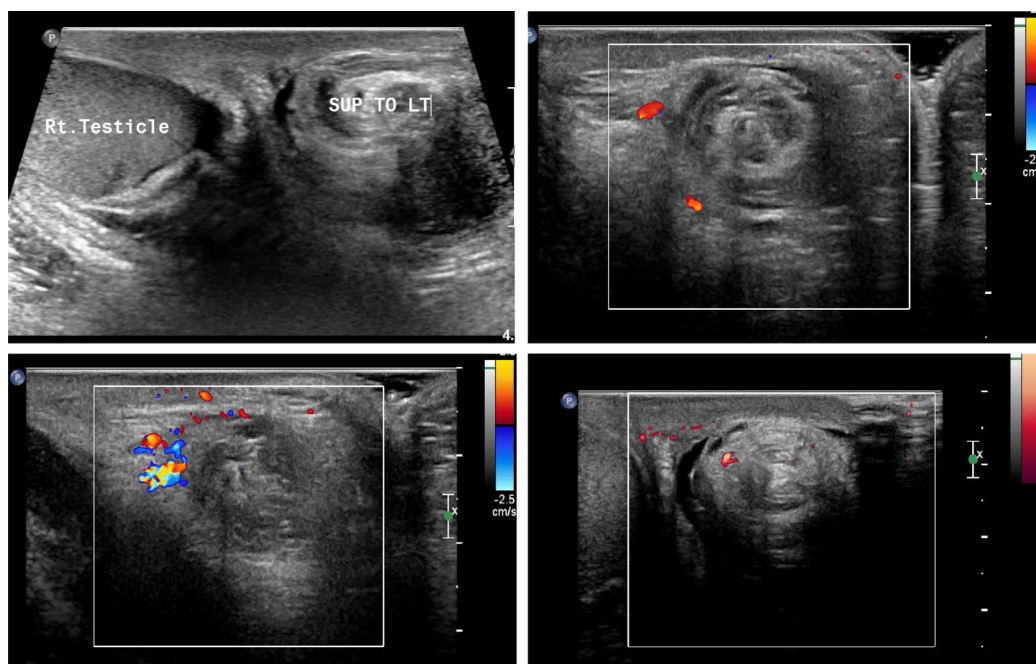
Testicular torsion: Gray-scale, color, and power Doppler assessment of the testes. The right testicle is homogeneous in echotexture and morphologically normal in appearance. There is an abnormal lie of the left testis with swirling of the spermatic cord (whirlpool sign) and diminished flow seen on color and even on power Doppler interrogation. (Color version of figure is available online.)
